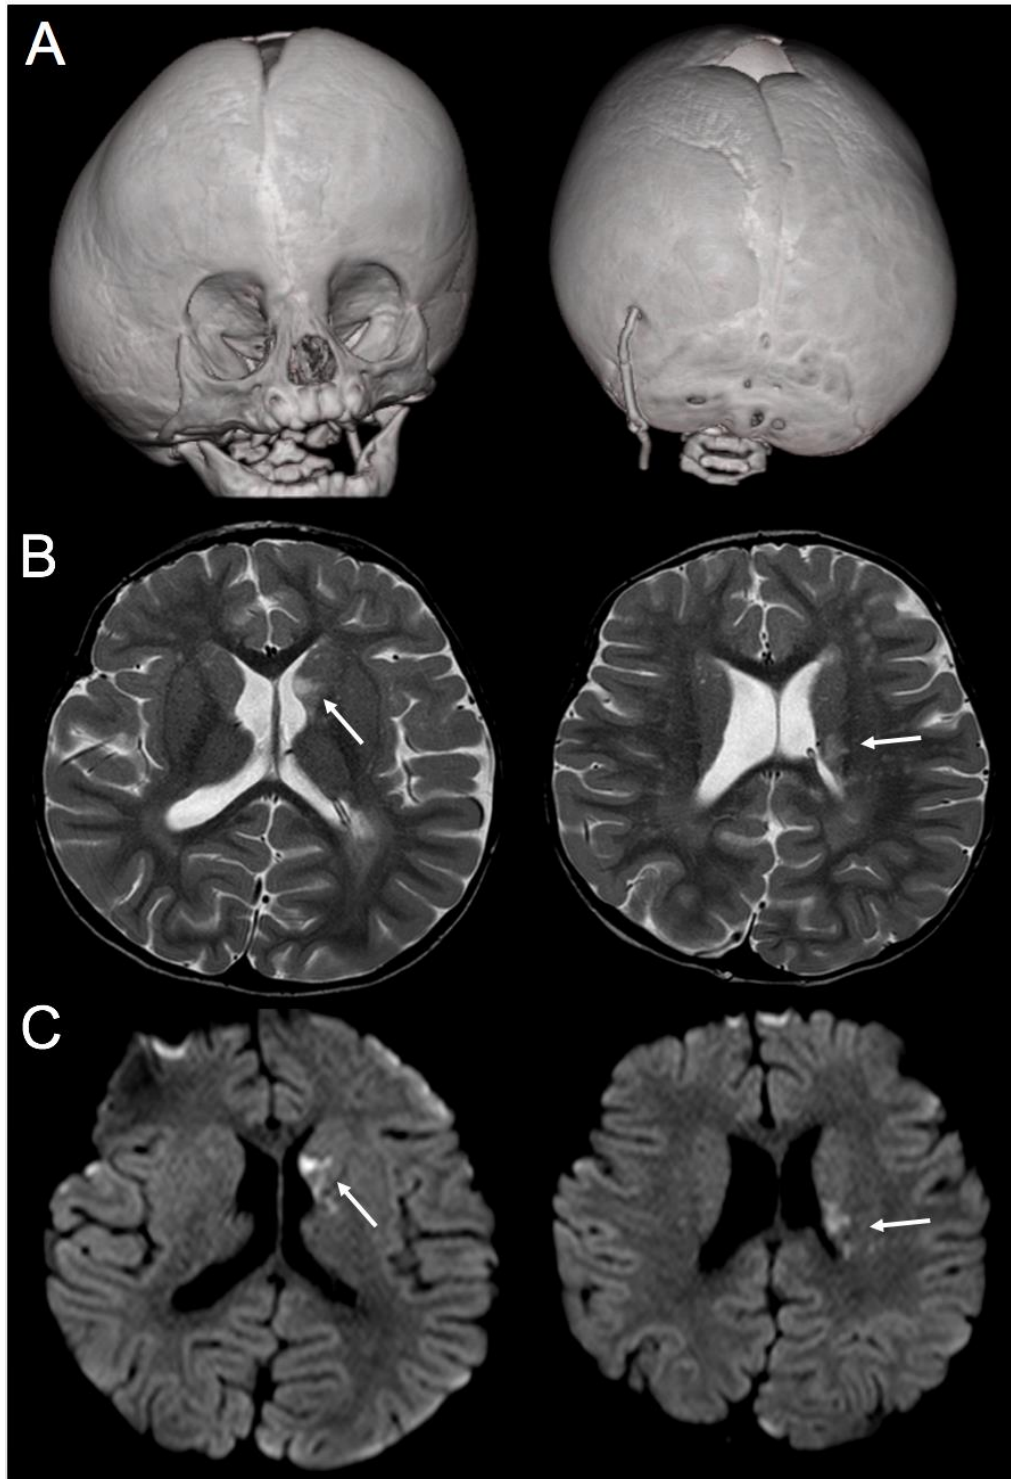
Neuroimaging of patient #1. A) Brain CT with 3D reconstruction. B, C) Brain MRI with multiple unilateral synchronous AISs in left MCA perforating arteries territory, without arteriopathy; multifocal bilateral WM lesions and ventricular dilatation
